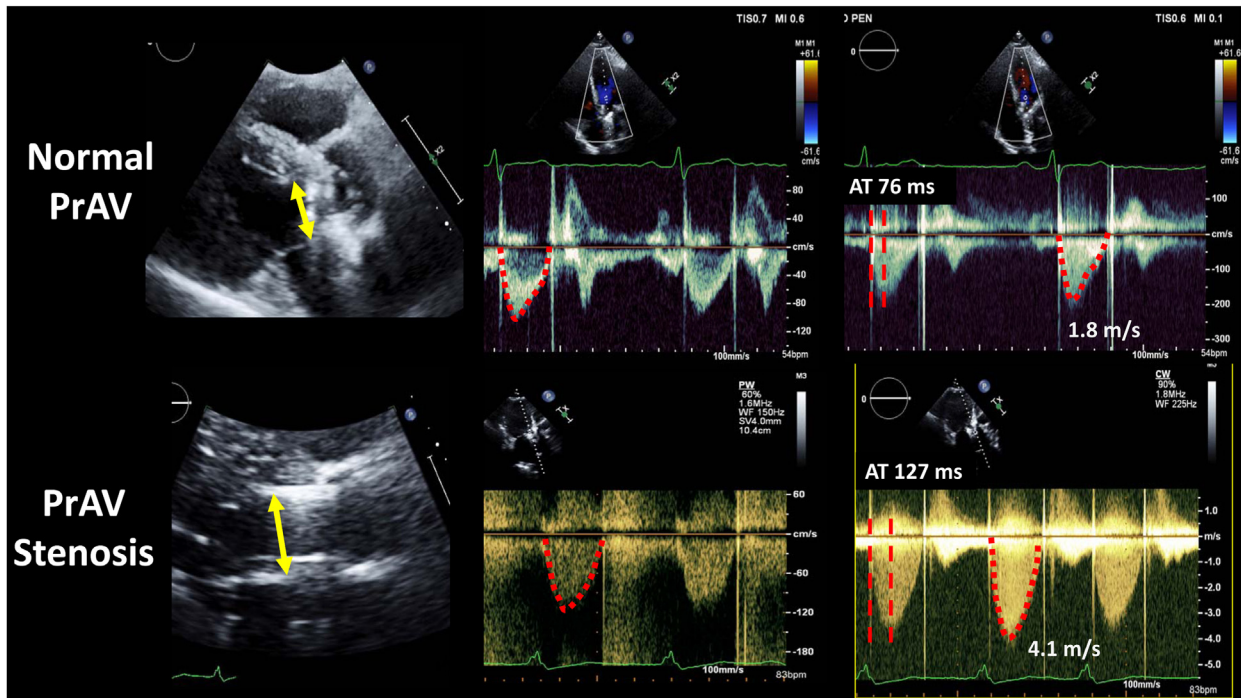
Doppler echocardiographic findings in a normal and a stenotic mechanical aortic valve showing the difference in velocity and its contour, and acceleration time (AT). Normal valve: LVOT diameter 2 cm, VTI_{LVOT} 19 cm, VTI_{PrAV} 31 cm, DVI 0.6, and EOA 1.92 cm². The calculated ratio of AT to ejection time (ET) is normal at 0.24. Stenotic valve: LVOT diameter 2 cm, VTI_{LVOT} 24 cm, VTI_{PrAV} 98 cm, DVI 0.24, EOA 0.77 cm², and calculated AT/ET ratio 0.4. *PrAV*, Prosthetic aortic valve.
